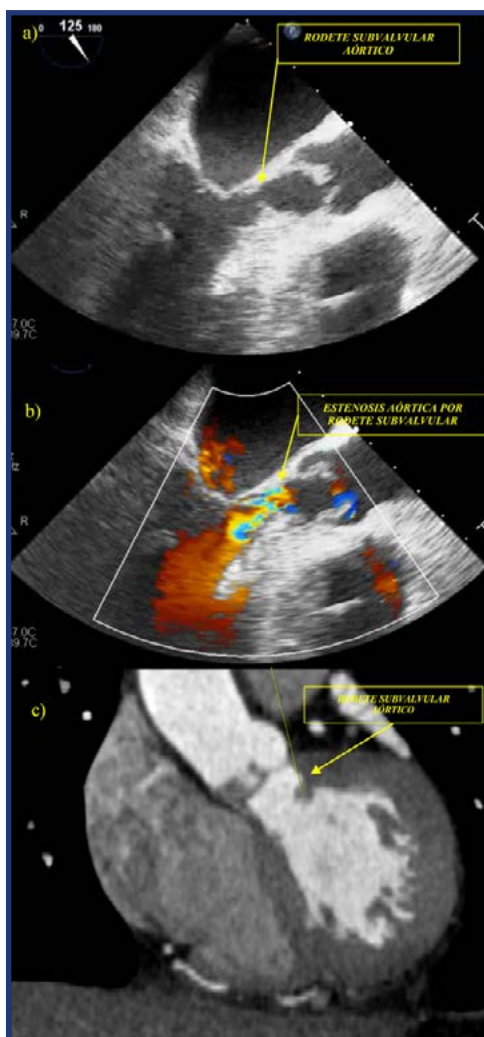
Transesophageal echocardiography: A) Aortic subvalvular ridge with aortic outflow obstruction; aortic ring 0.93 cm. B) Doppler: aortic subvalvular ridge is observed creating stenosis. C) Thorax angio CT: evidence of aortic subvalvular ridge with a valvular area of 0.98 sq. cm, accessory mitral tissue, reduction of left ventricle outflow tract of 0.68 cm².
